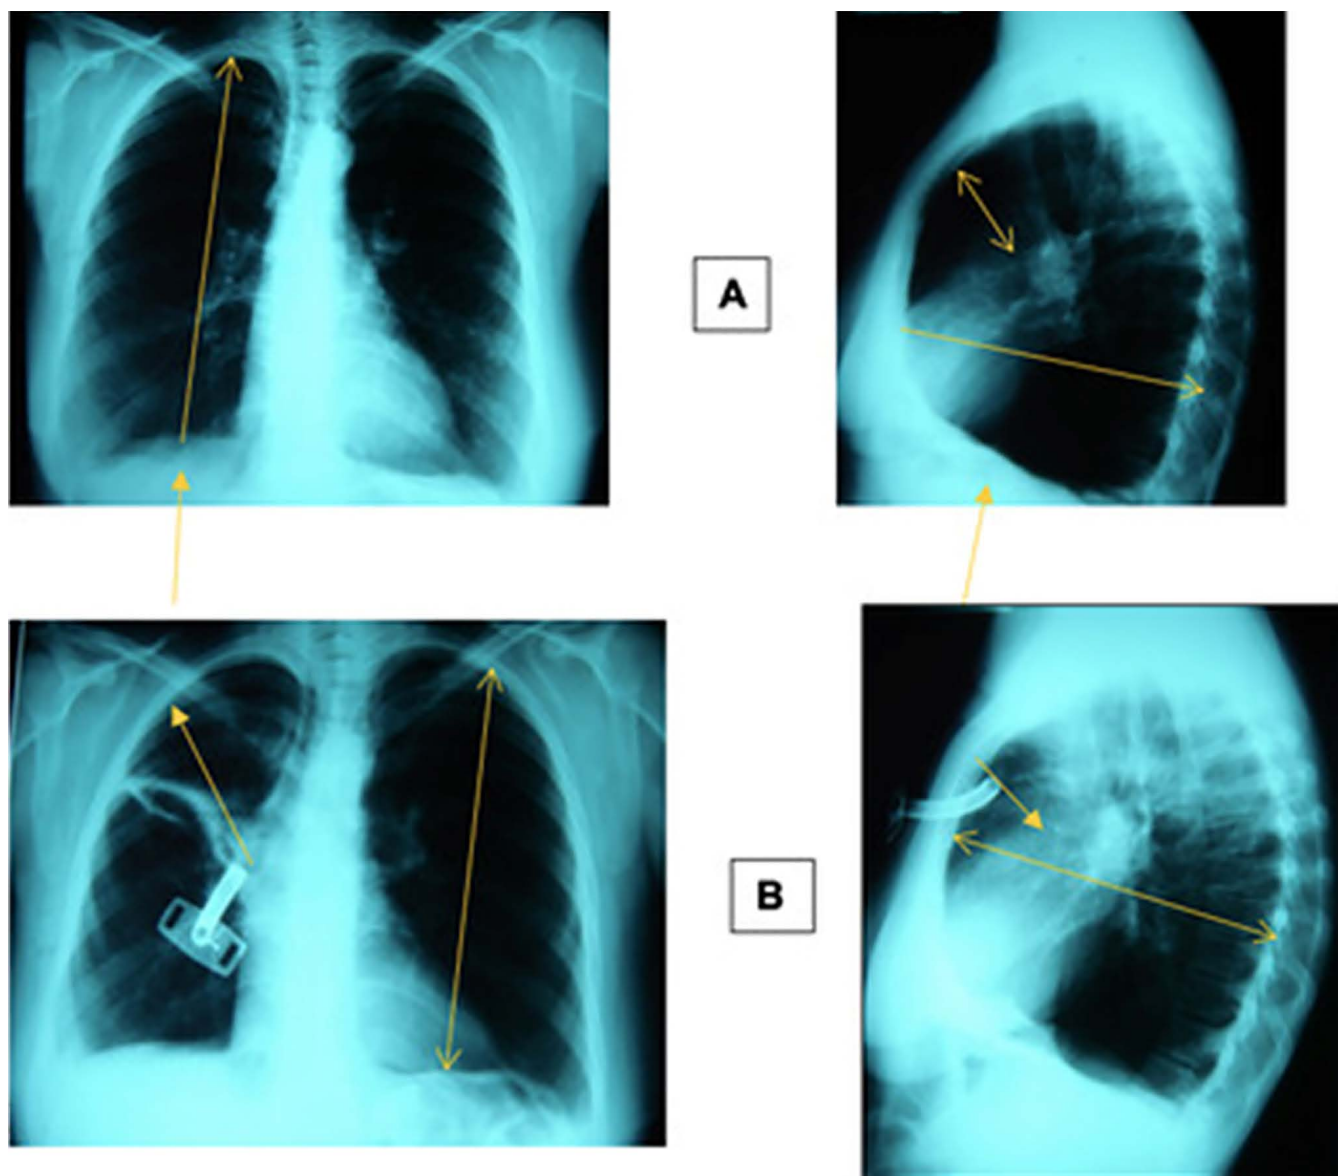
Chest X-ray in AP and profile: A) preoperative; B) post-operative
